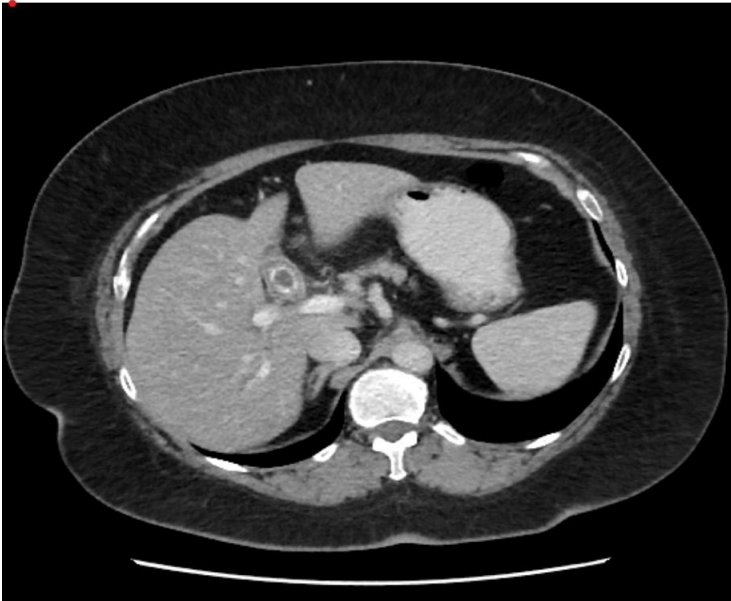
CT scan shows large stone within the bile duct.
